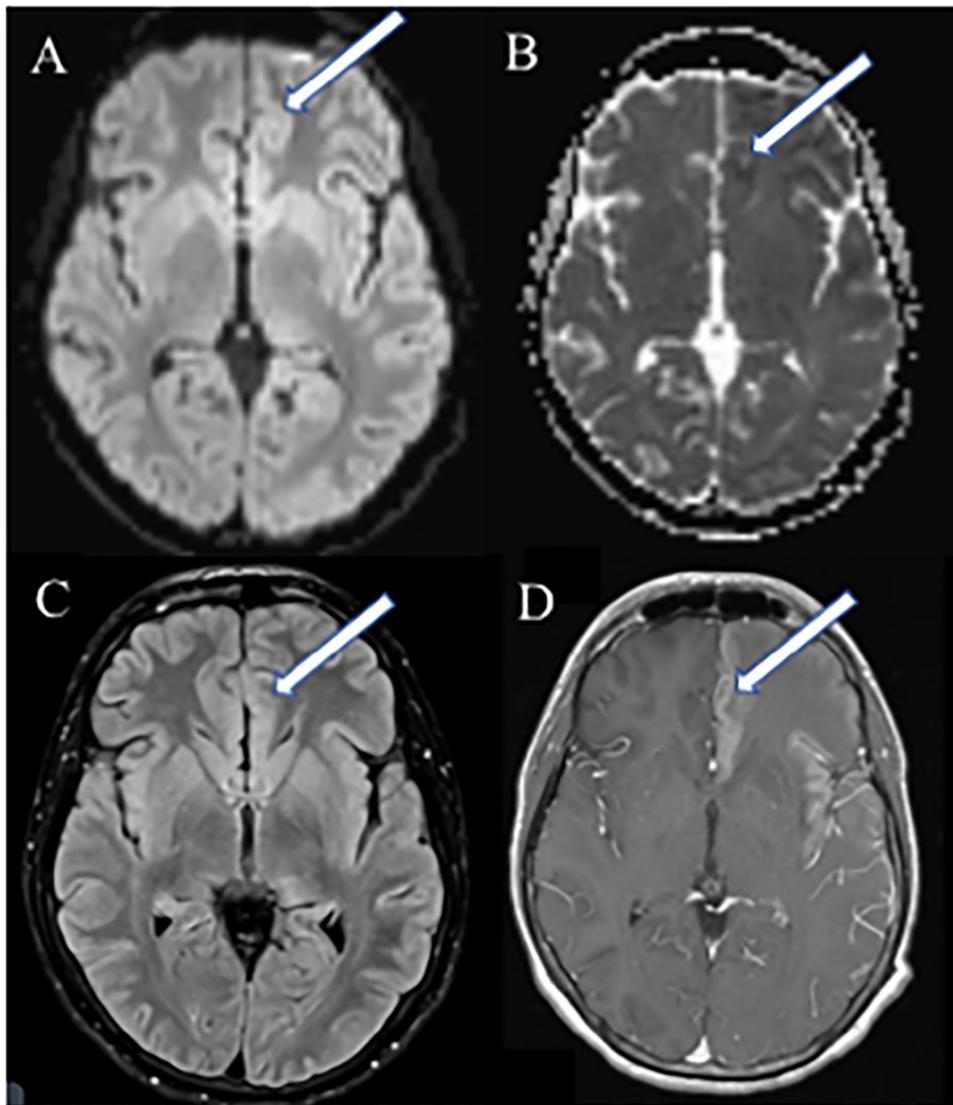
Common MRI findings due to status epilepticus. DWI (A) sequence reveals increased intensity in the left insular and frontal cortices (white arrows) with corresponding decreased apparent diffusion coefficient (ADC, B). There are similar regions of increased intensity on FLAIR imaging (C) and contrast enhancement (D) implying a component of vasogenic edema. These changes resolved on repeat MRI one week later.
